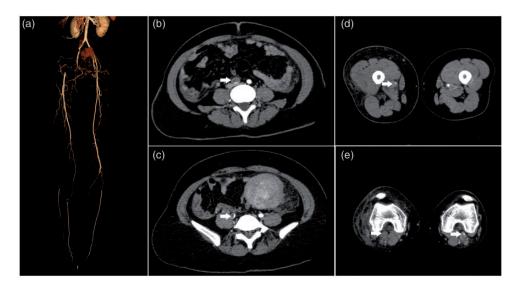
Computed tomography angiogram of the patient. (a) Arterial thrombosis in the lower extremities can be seen. Thrombi in the right common iliac artery (b), the right internal iliac artery (c), the right lower femoral artery (d), and both sides of the popliteal artery (e) can be seen. White arrows indicate thrombi in arteries.
